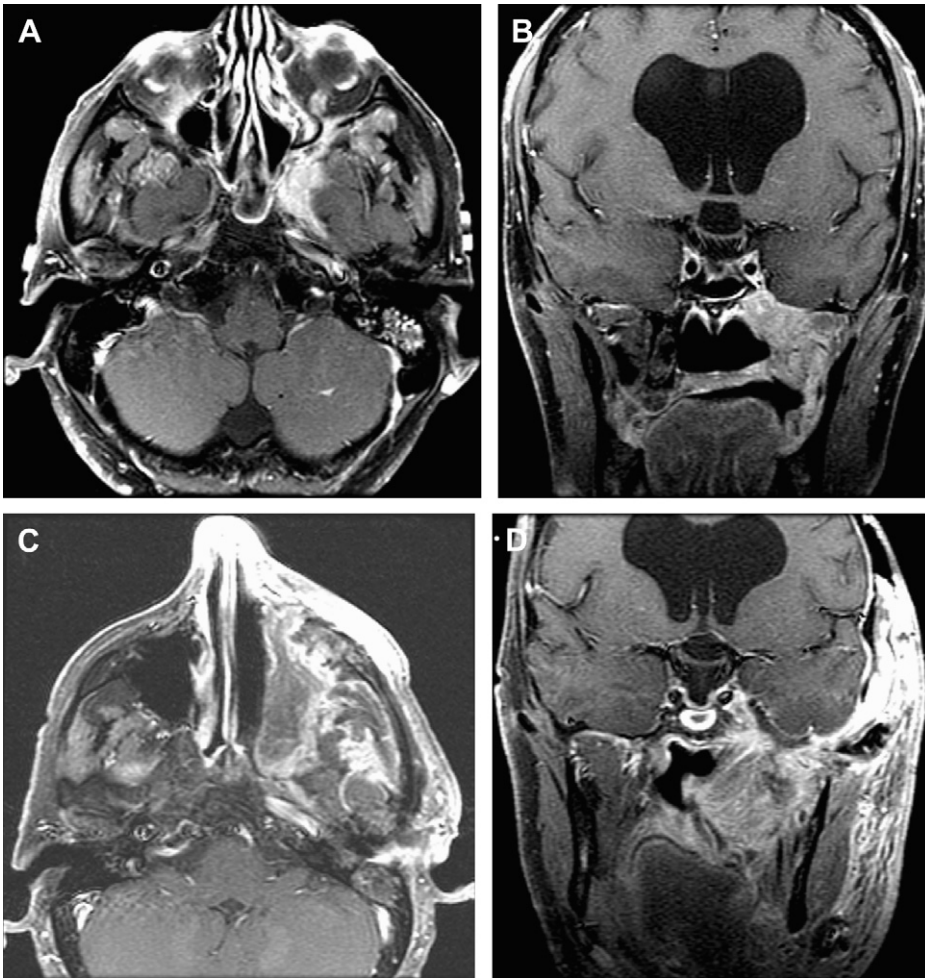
Axial (A) and coronal (B) postcontrast T1-weighted MRI of a male patient with a recurrent malignant fibrous histiocytoma of the left infratemporal fossa and anterolateral skull base. He underwent a transfacial and anterolateral skull-base approach with complete tumor removal. Reconstruction with a free anterolateral thigh flap was performed following watertight dural closure. Final pathology was read as pleomorphic sarcoma. Postoperative axial (C) and coronal (D) postcontrast T1-weighted MRI confirmed complete tumor removal. Chemoradiation is planned. (Courtesy of Department of Neurosurgery, The University of Texas M.D. Anderson Cancer Center; with permission.)
